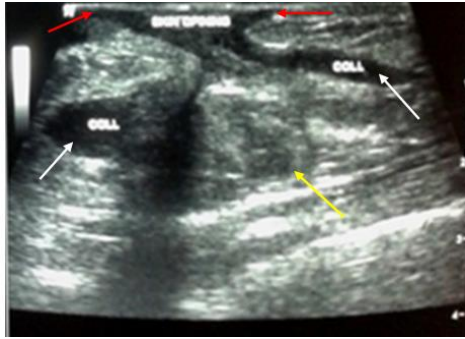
Breast ultrasonography of right breast with IGM demonstrates an ill-defined, irregular lesion of mixed echogenicity (yellow arrow), hypoechoic mass lesions of subcutaneous collections (white arrows) which corresponds to multiple subcutaneous abscesses that open into the skin with mammary duct fistulae (red arrows).
